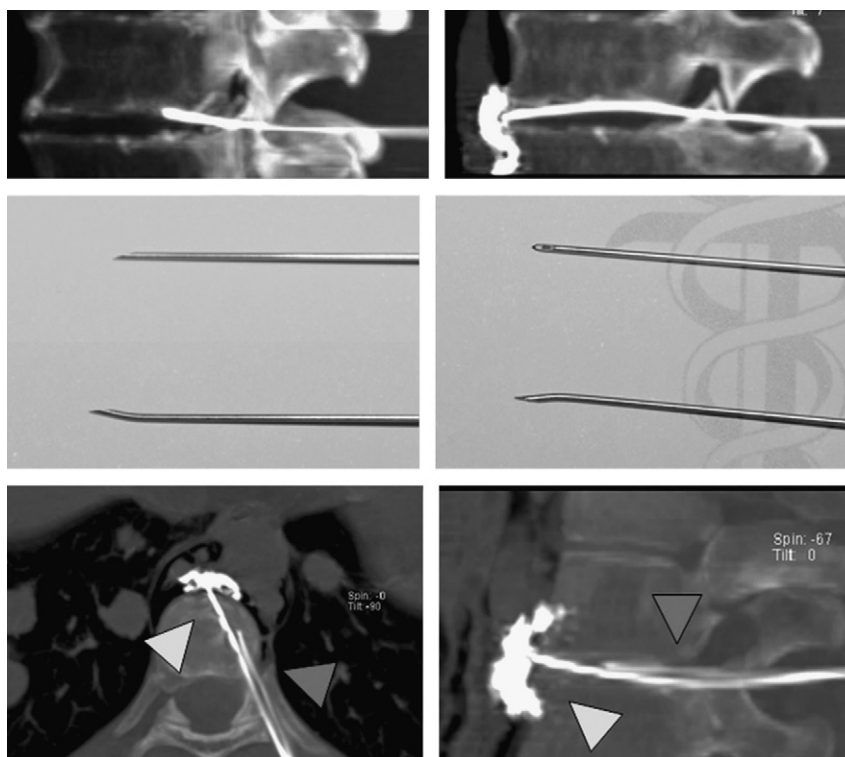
Instructions for the curved needle technique. Comparison with the straight needle technique. Top left and top right: Sagittal view of the CT scan of the 2 types of needles. Top left, A straight tip may render difficult a smooth navigation through the disk if it bumps into the vertebral plateau. Top right, A bent tip allows the needle to cross the disk more easily and to continue its navigation into the prevertebral space (contrast). Mid left, Lateral view comparing the tips of 2 actual needles: classic straight (on top) and modified curved (on bottom). Mid right, Lateral and frontal view of a curved needle showing how the curvature at the bevel does not interfere with the bore at the tip. Bottom left and bottom right: Computed tomographic scan of a patient where 2 parallel needles were inserted, one with a straight end (red arrowhead) and another one with a curved end (yellow arrowhead). Bottom left, The bent needle is able to reach the posterior mediastinum, whereas the straight does not (axial view). Bottom right, The straight tip bumps against the vertebral plateau, but the curved end navigates through the disk (sagittal view).
